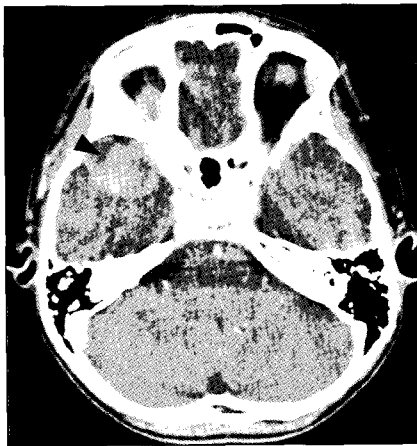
Axial computed tomography(CT) scans showing an arachnoid cyst in the right temporal region and intracystic hemorrhage (arrowhead).
